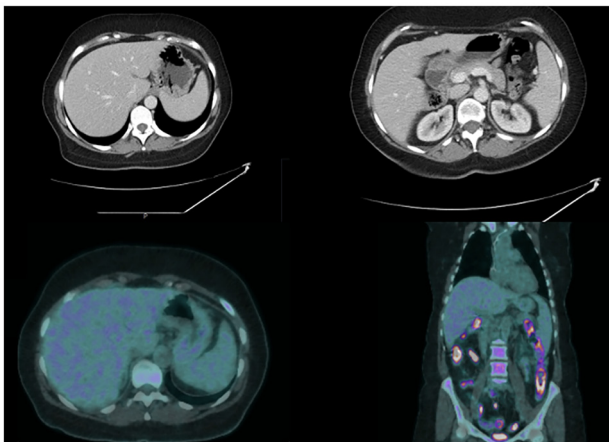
Decision for resection. CT and FDG-PET June 2021 show absence of liver disease, regression of the primary tumour, and complete metabolic response.
